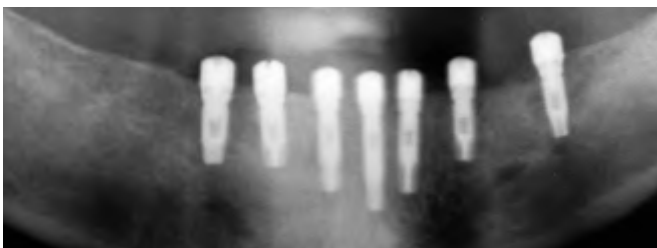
Panoramic radiograph of a patient immediately post placement of seven mandibular implants with a two-stage surgical protocol. The left and right distal implants were placed distal to the mental foramen.
